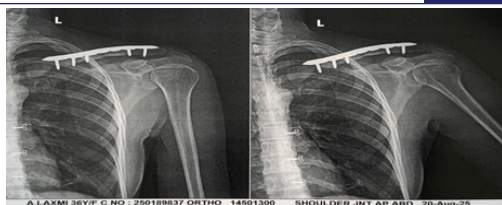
Postoperative AP Radiograph of Left Clavicle Showing Plate Fixation with Satisfactory Alignment
